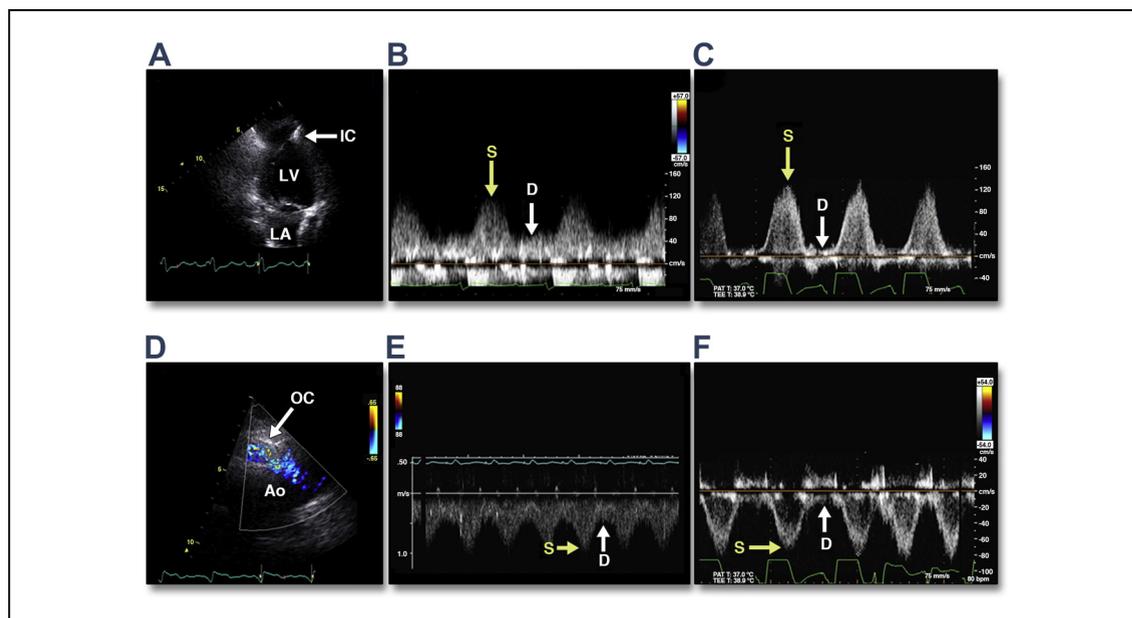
LVAD Inflow and Outflow Cannula With Doppler Flow Waveforms at Baseline and at Presentation With IVH Due to Suspected Pump Thrombosis
